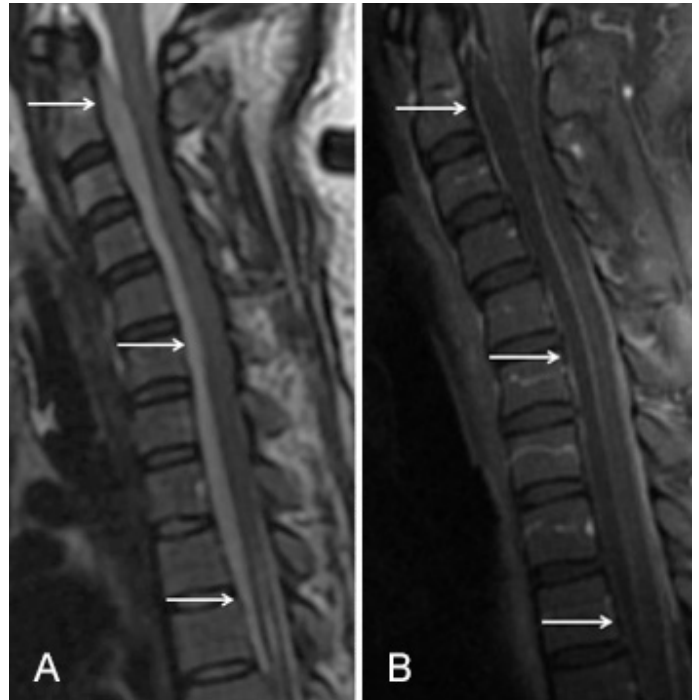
A 37-year-old woman presenting with posterior neck pain and fever for five days. She admits injecting heroin over the past year. Sagittal T2-weighted (A) and contrast-enhanced T1-weighted (B) magnetic resonance images show a mildly T2 hyperintense T1 hypointense peripherally enhancing fluid collection consistent with an epidural abscess extending along the ventral aspect of the spinal canal from the level of C2 through the T3 level (arrows).
